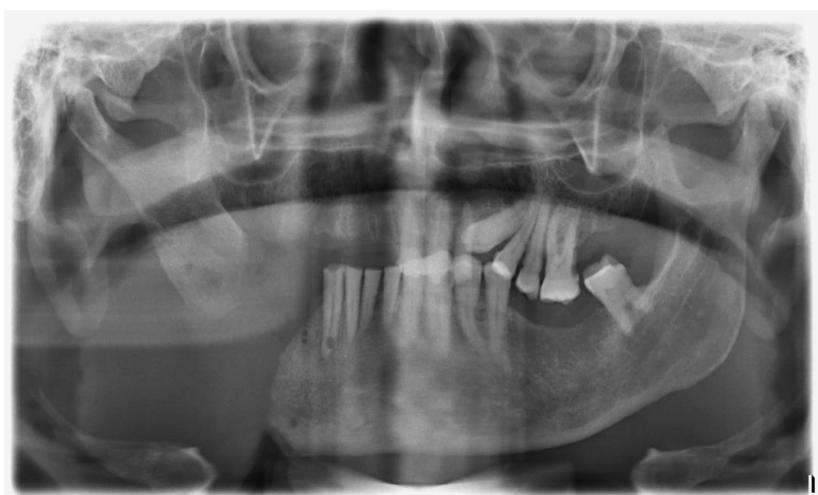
Orthopantomograph showing segmental mandibular resection
